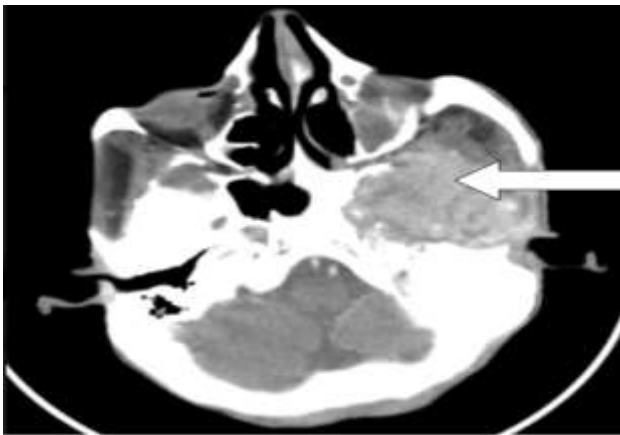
CT scan of mass in infra temporal fossa.
